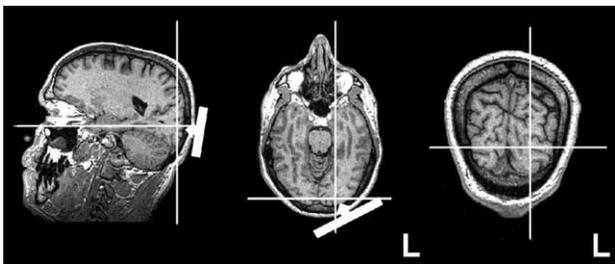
TMS site of one exemplar subject relative to his MR image. The cross-hairs highlight the cortical point located radially inward from the center of the coil as extrapolated using a frameless stereotaxic system (see coil outline on sagittal and transverse slices). Scalp coil positions have been determined functionally and in each subject separately, i.e. TMS was applied to an occipital spot close to midline where magnetic stimulation evoked contralateral phosphenes overlapping with the position of the visual checkerboard.
